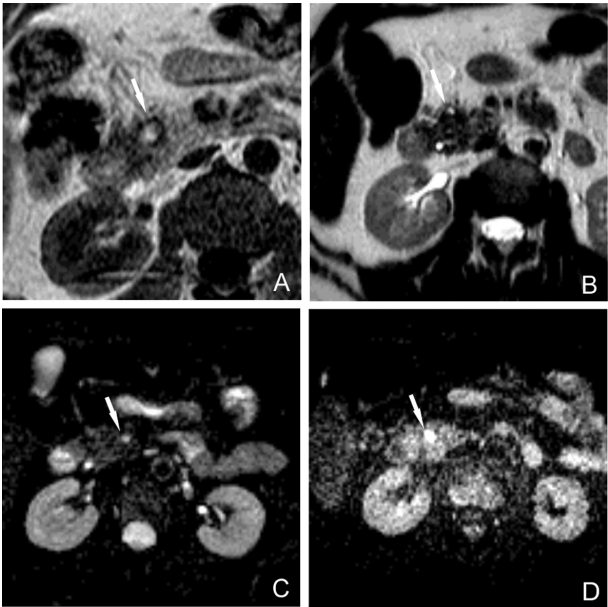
Small cephalopancreatic cyst containing mucoproteins. (A) T1 weighted sequence shows a fluid-fluid level with hyperintensity of declive protein component. (B) Weak hyperintensity of overlying liquid component in T2w sequence. (C-D) DWI sequences with b values 0 and 800 show restricted diffusion due to viscosity content (false positive)
